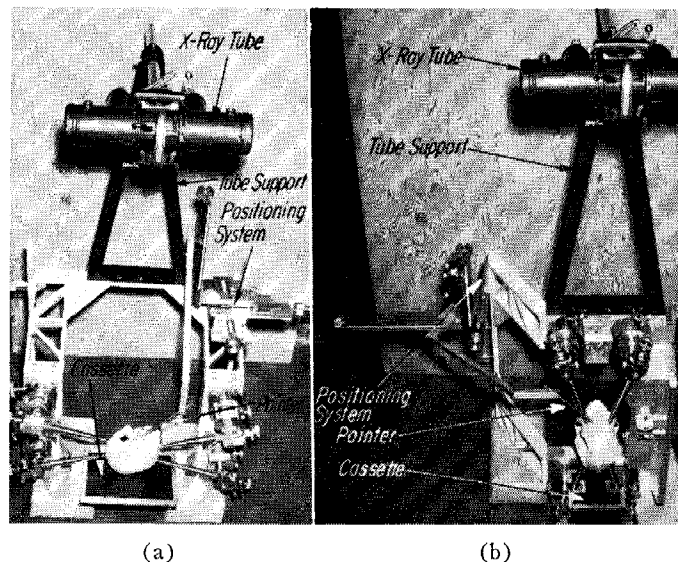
(a) Human head holder showing X-ray tube in position for a lateral picture. (b) Human head holder showing X-ray tube in position for an anterior-posterior picture.*
